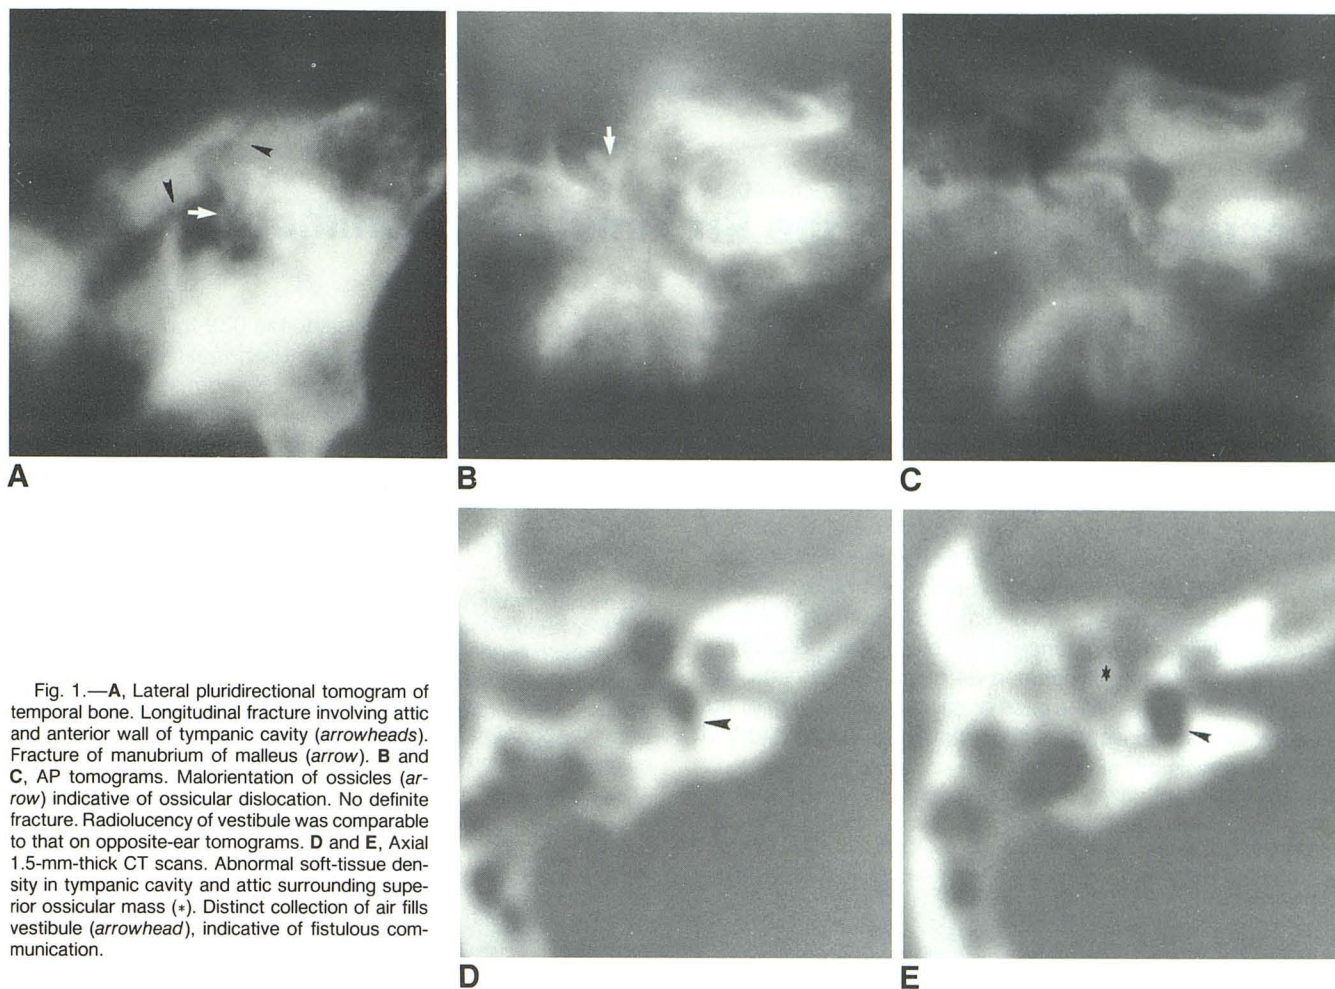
A, Lateral pluridirectional tomogram of temporal bone. Longitudinal fracture involving attic and anterior wall of tympanic cavity (arrowheads). Fracture of manubrium of malleus (arrow). B and C, AP tomograms. Malorientation of ossicles (arrow) indicative of ossicular dislocation. No definite fracture. Radiolucency of vestibule was comparable to that on opposite-ear tomograms. D and E, Axial 1.5-mm-thick CT scans. Abnormal soft-tissue density in tympanic cavity and attic surrounding superior ossicular mass (*). Distinct collection of air fills vestibule (arrowhead), indicative of fistulous communication.
